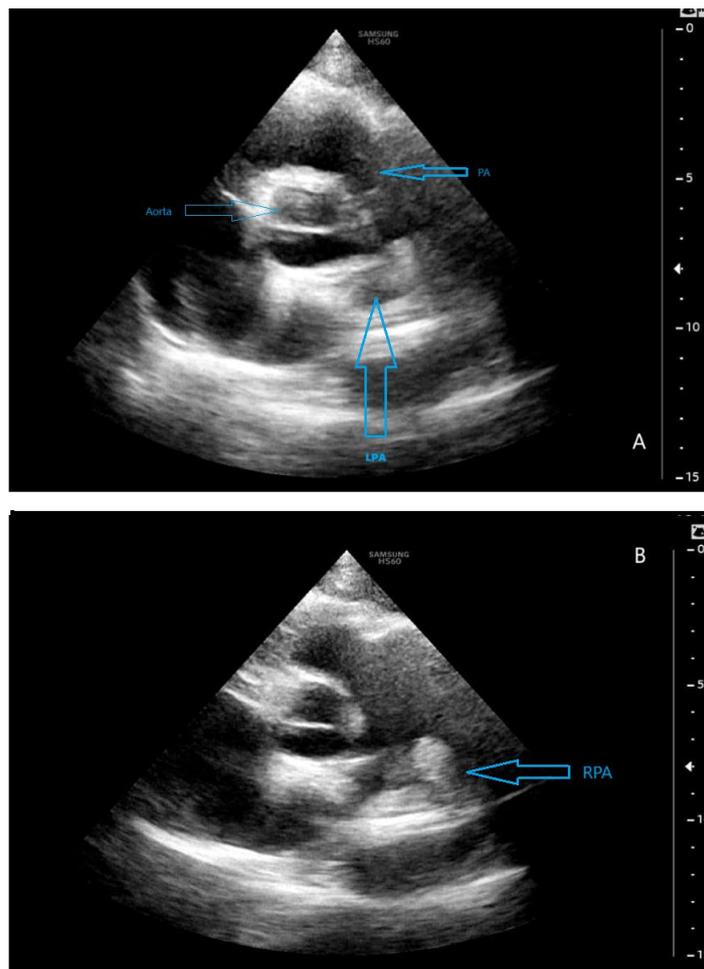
Parasternal short axis echocardiographic view. A) thrombus in the left PA B) Thrombus in the right PA.
